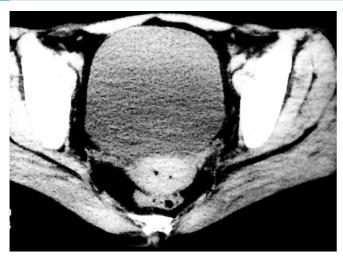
CT scan displays a cervical mass posterior to the urinary bladder with air pockets within it suggestive of ulceration. (*Courtesy*: Dr Shashi Paul)
